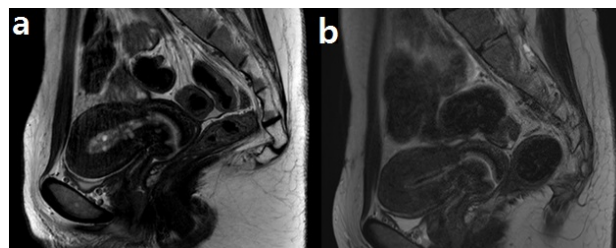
T2-weighted MRI at the time of diagnosis and three months after the treatment. (a) Sagittal view of preoperative MRI at the time of diagnosis. (b) Sagittal view of postoperative MRI, three months after the surgery.
